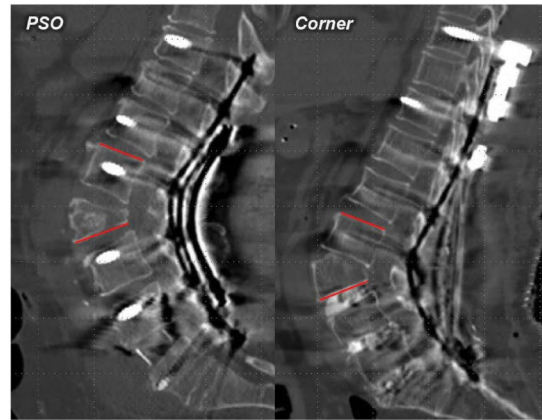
Comparison of correction angle through segmental angle measurement of osteotomy site on CT
